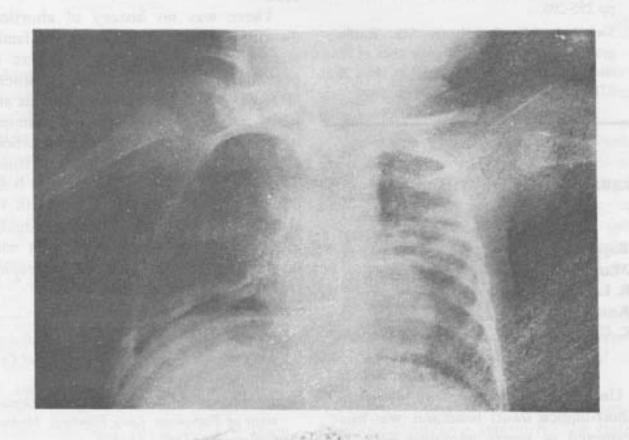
Roentgenogram showing Sprengel's deformity of right scapula, absent right upper thoracic ribs and other anomalies.
